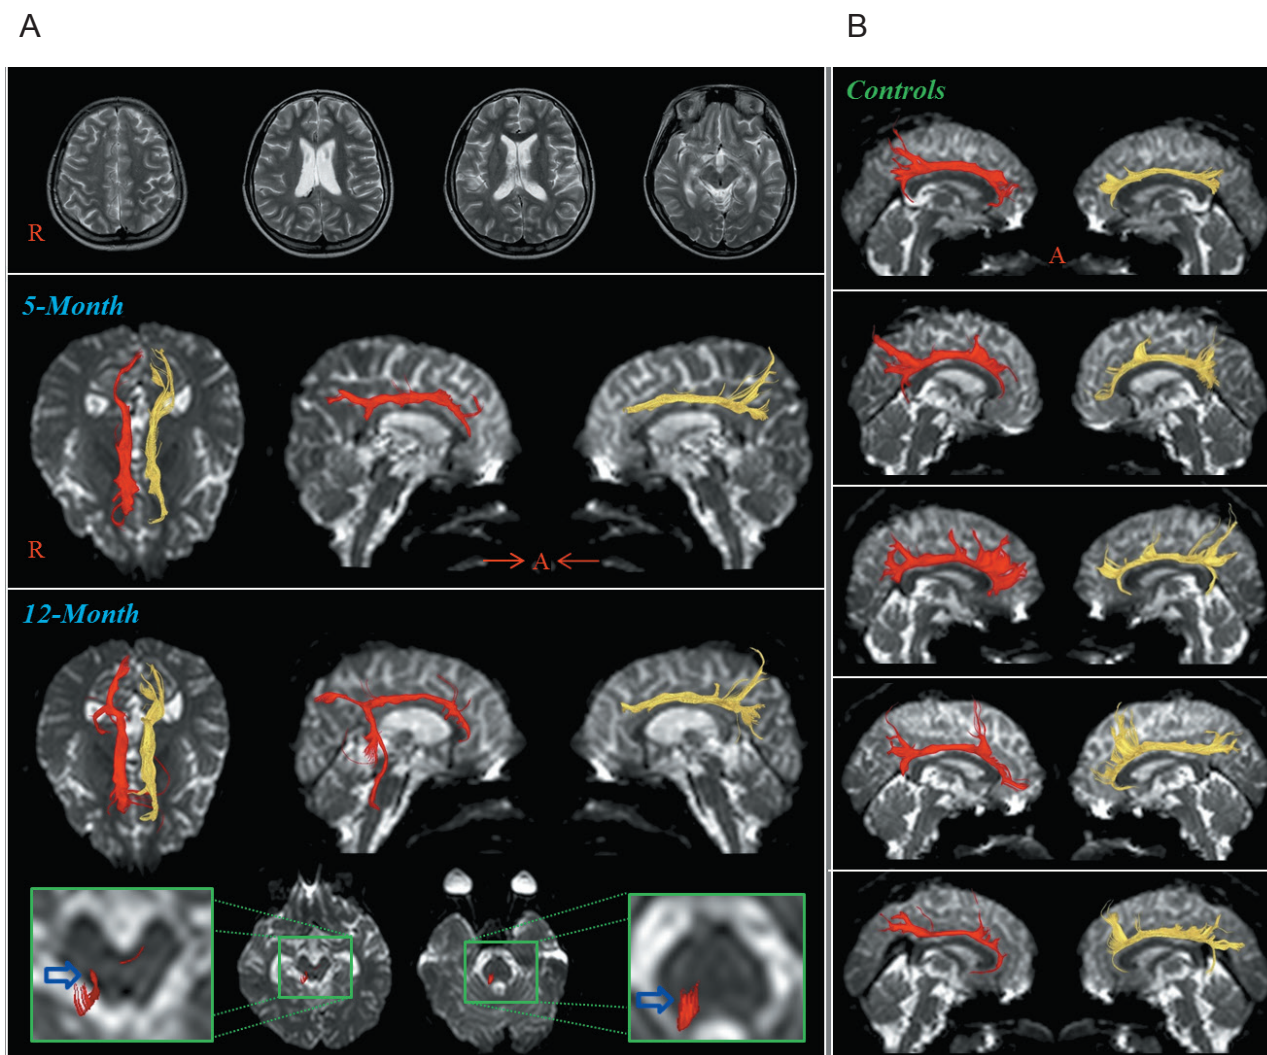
Conventional magnetic resonance (MR) images and diffusion tensor tractography (DTT) images of a 13-year-old male patient with traumatic brain injury. (A) T2-weighted MR images showed no specific lesions. On both 5-month and 12-month DTT images, discontinuations were observed in both anterior cingulums (yellow: left, red: right). On 5-month DTT, we did not observe any neural bypass between injured cingulum and brainstem cholinergic nuclei. However, on 12-month DTT images, a neural bypass (blue arrows) was observed between the right injured cingulum and right brainstem cholinergic nuclei (Ch 6 and 8; blue arrows). (B) No neural bypass was observed between injured cingulum and brainstem cholinergic nuclei in five age-matched control subjects. R: Right; A: anterior.
